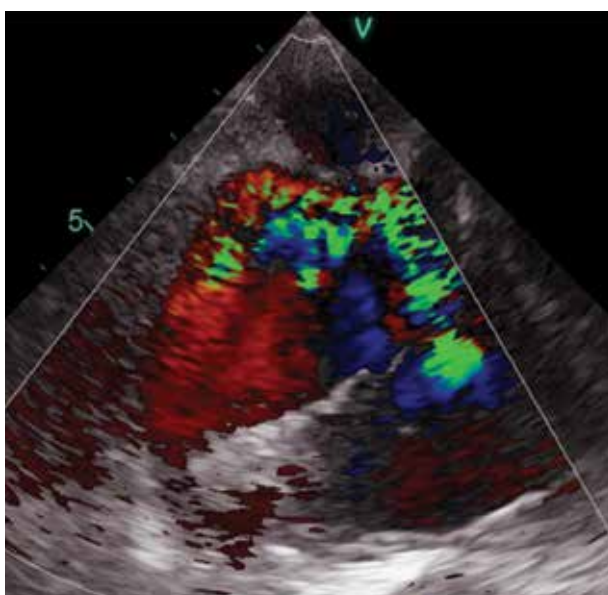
Transesophageal mid-esophageal four-chamber view: jet of tricuspid regurgitation.
